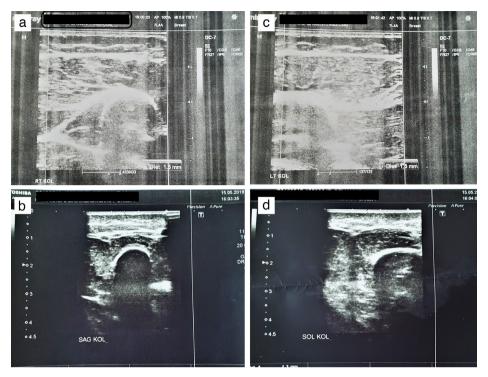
(a) Pretreatment ultrasonographic skin thickness of the right arm: 1.5 mm, (b) post-treatment ultrasonographic skin thickness of the right arm: 1.2 mm, (c) pretreatment ultrasonographic skin thickness of the left arm: 1.5 mm, and (d) post-treatment ultrasonographic skin thickness of the left arm: 1.3 mm
